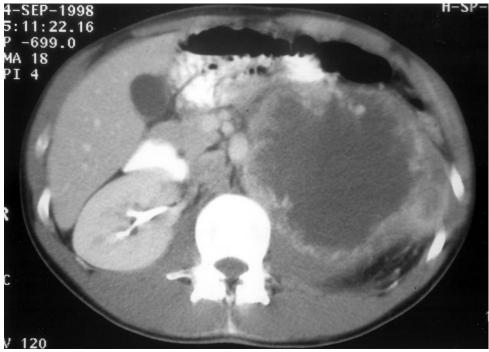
CT scan of abdomen revealing large retroperitoneal tumor (Case 3).
